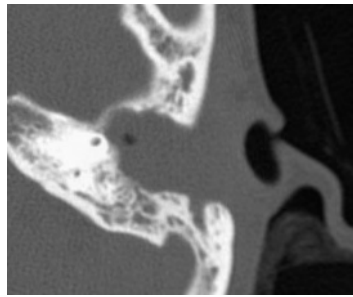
CT scan image before the first-stage operation. No aeration can be seen in the attic and mastoid cavity.
